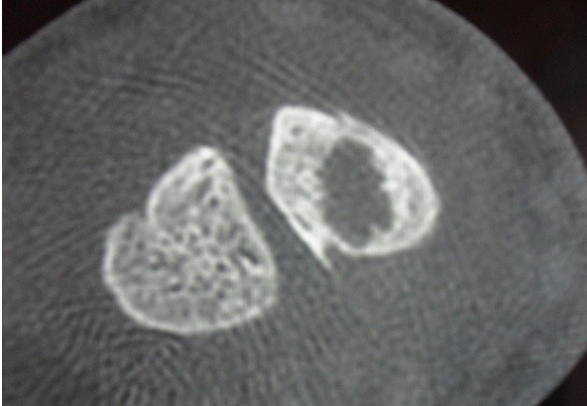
Transverse CT-scan confirmed a cystic lesion of the scaphoid and was able to localize the lesion and the fracture precisely. Other carpal bones and adjacent joints were normal
